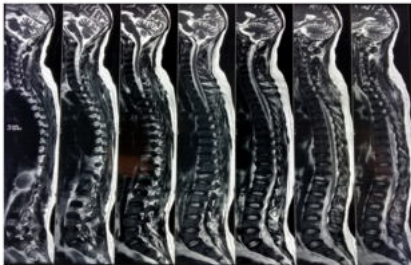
MRI spine showed patchy multifocal areas of altered signal intensities in the muscle.
